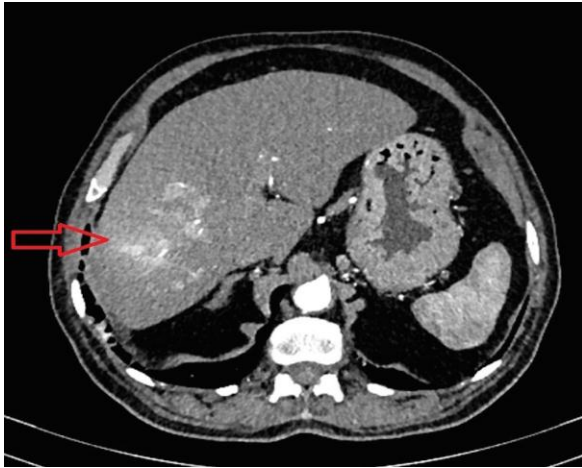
Axial soft-tissue window CT image during arterial phase showing an enhancing lesion in right lobe of liver (marked with red arrow).
